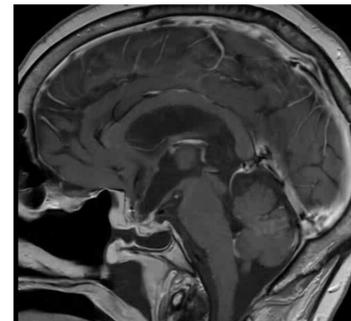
postoperative, post-contrast magnetic resonance image in the sagittal view showing complete resection of the large pituitary macroadenoma referenced in Figure 1 without evidence of residual tumor
